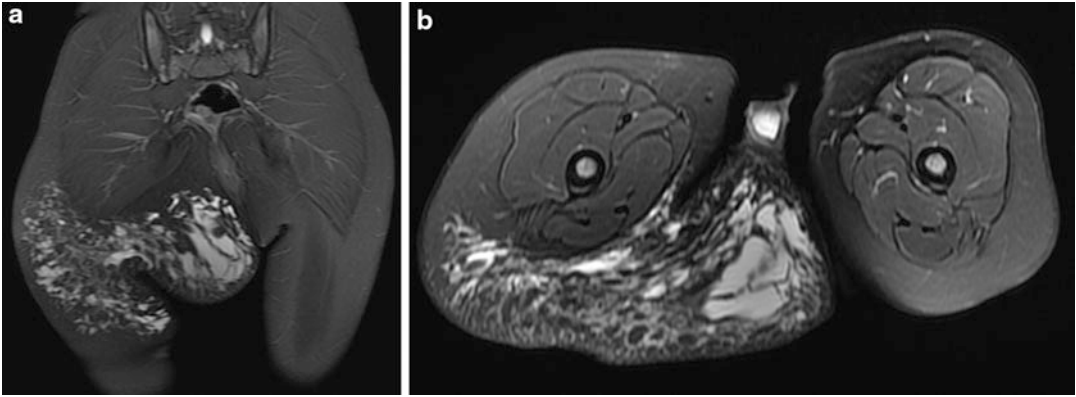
(a, b) This patient was a 2-year 3-month-old male who presented for evaluation of his swollen right buttock. The parents noticed discrepancy in the size of buttocks after birth. The mother felt that the right buttock had been enlarging. There was no drainage, discolorations, or tenderness noticed. MRI (a, b) showed a large infiltrating
